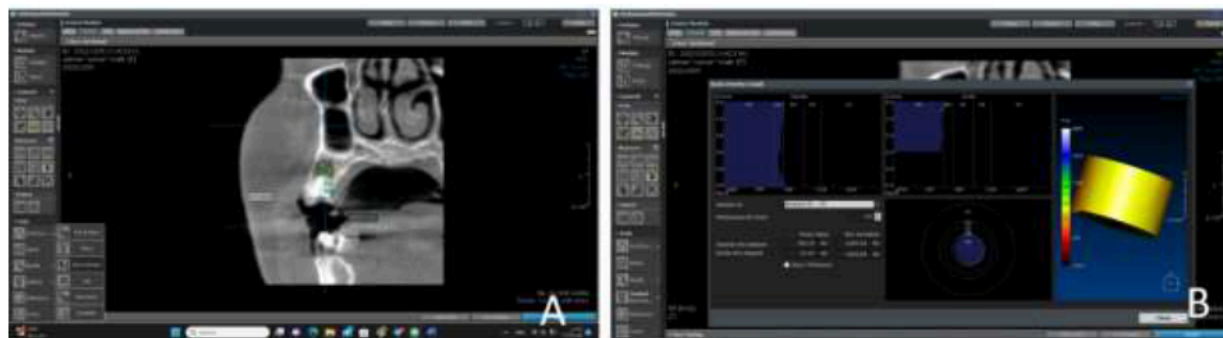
The preoperative assessment and measuring of the bone density at the apical region of the accused tooth by CBCT. (A) A coronal view assessed the upper right second premolar retained root bone width and height with the placement of a virtual box (3mm height, 5 mm width) apical to the root apex. (B) the estimated bone density inside that virtual box.
